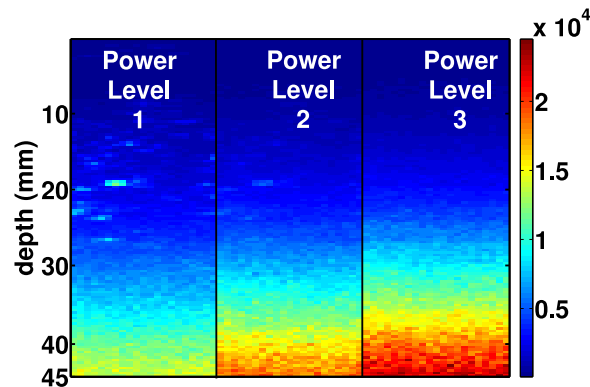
The noise level at different depths for three different decreasing transducer acoustic power settings ( $0\text{ dB}$ ,  $-2\text{ dB}$  and  $-6\text{ dB}$ ). The data was acquired by mounting the probe in a large water container with no tissue involved. The noise level is calculated based on the method described in Section 6.6.2 and mapped onto the ultrasound image. Noise amplitude increases at deeper areas and in lower power levels. The increased level of noise decreases the SNR in the backscattered echoes and reduces the accuracy.
